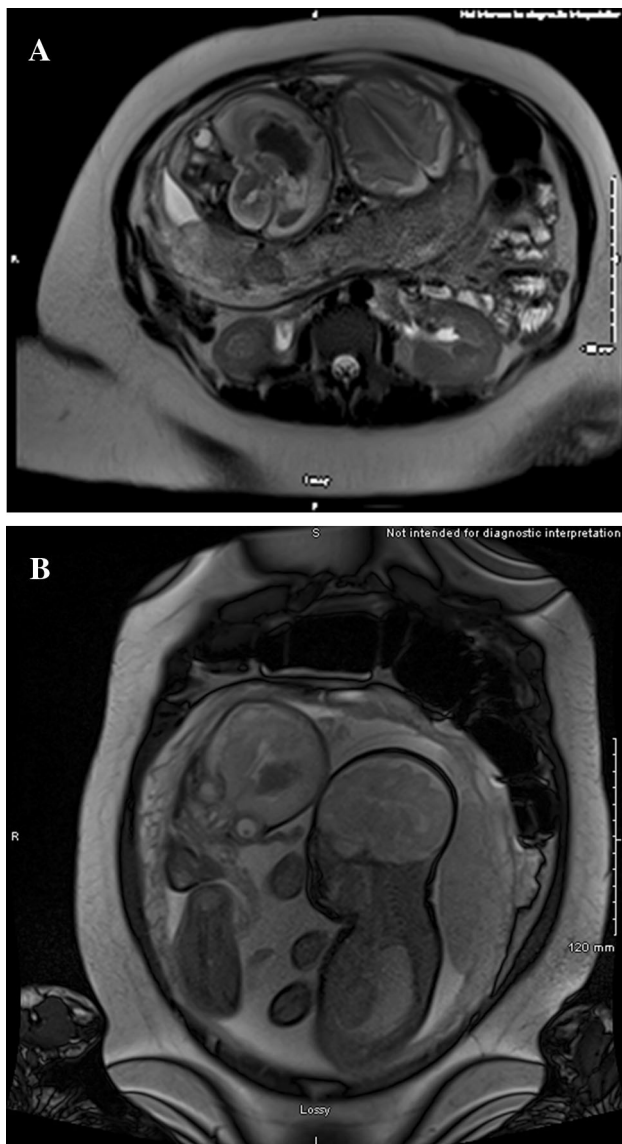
Axial (a) and coronal (b) MRI of the mother at 30.2 weeks' gestation. Fetus B (anatomic right) has markedly dilated ventricular system with large, grade IVH measuring $2.2 \times 2.9 \times 4.3$ cm in size. Periventricular hemorrhagic infarction was noted on the left with a midline shift to the right of approximately 2–3 mm related to mass effect from the IVH. Fetus A (anatomic left) has no evidence of neurologic abnormalities
